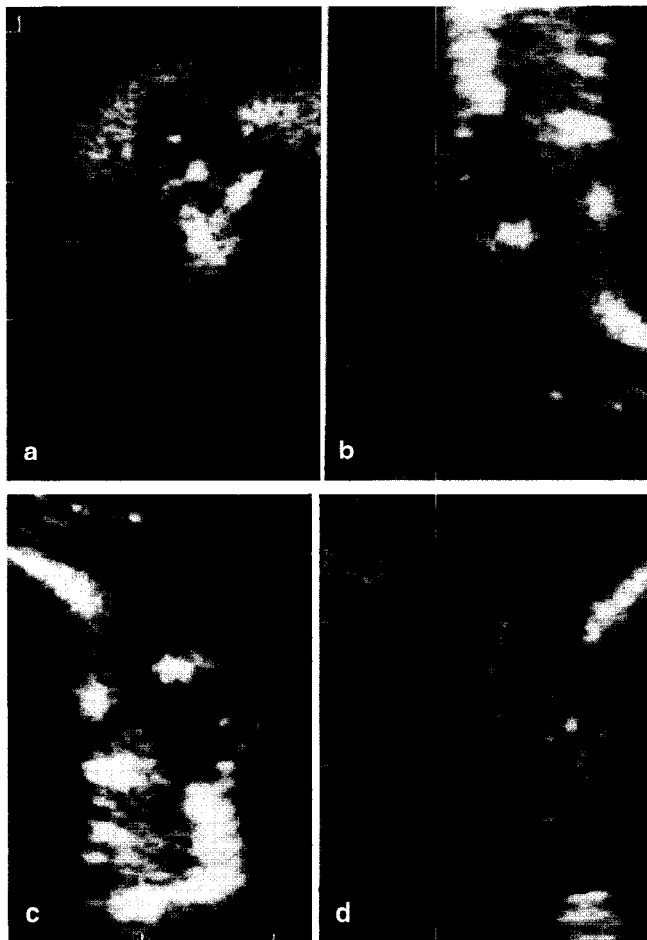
Transvaginal ultrasound image of the normal fetal orbits and lenses at 15 and 22 postmenstrual weeks in the normally developing first fetus. (a) Coronal view (15 weeks); (b) sagittal view (15 weeks); (c) sagittal view (22 weeks); (d) coronal view (22 weeks). Note that, regardless of the age and the view, the central part of the lens is completely sonolucent
